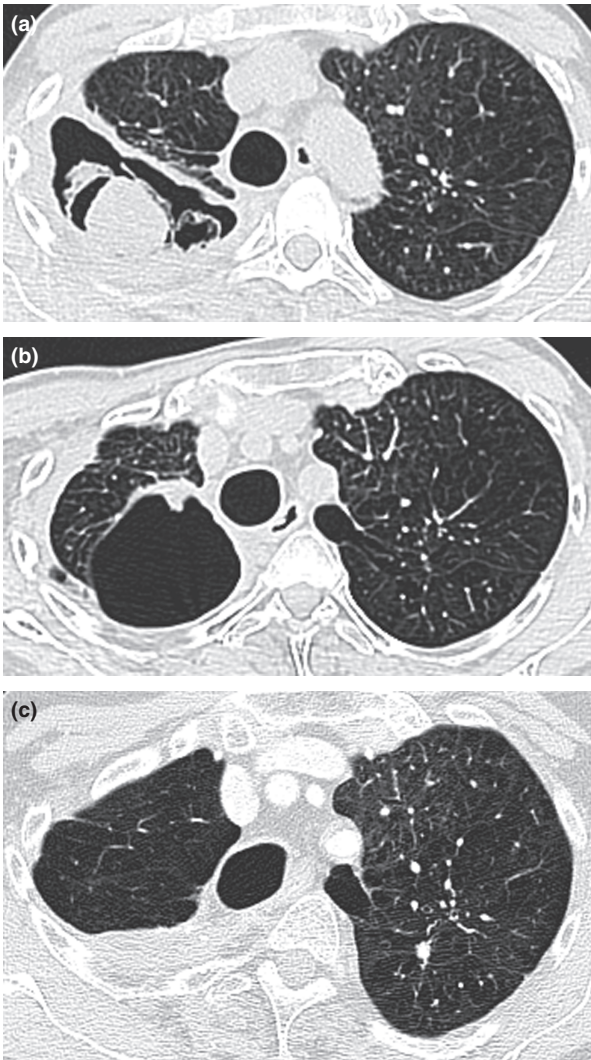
(a) Chest CT shows a fungus ball within a large thick-walled cavity in the right upper lobe. The aspergilloma had grown within that old cavity of former tuberculosis. Note severe emphysema of both upper lobes. (b) Chest CT reveals the empty cavity in the right upper lobe after surgical resection because of proven mobility of the aspergilloma. (c) Five years after resection, the empty cavity has diminished and a thickened dorsal pleura in the right upper lobe remains. At the time the patient complains about increased frequency of cough and expectorations, probably related to his underlying chronic obstructive pulmonary disease.
